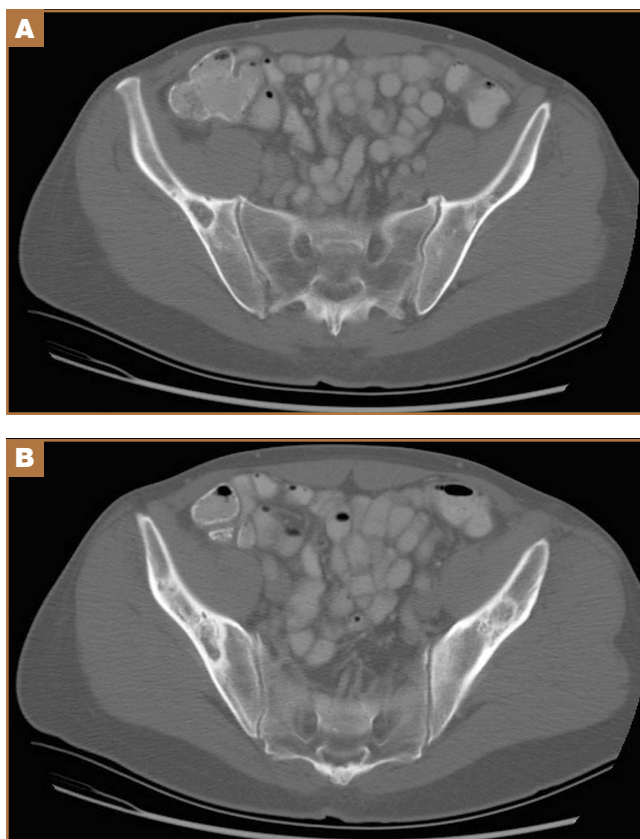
(A, B) Axial computed tomography images of pelvis.
